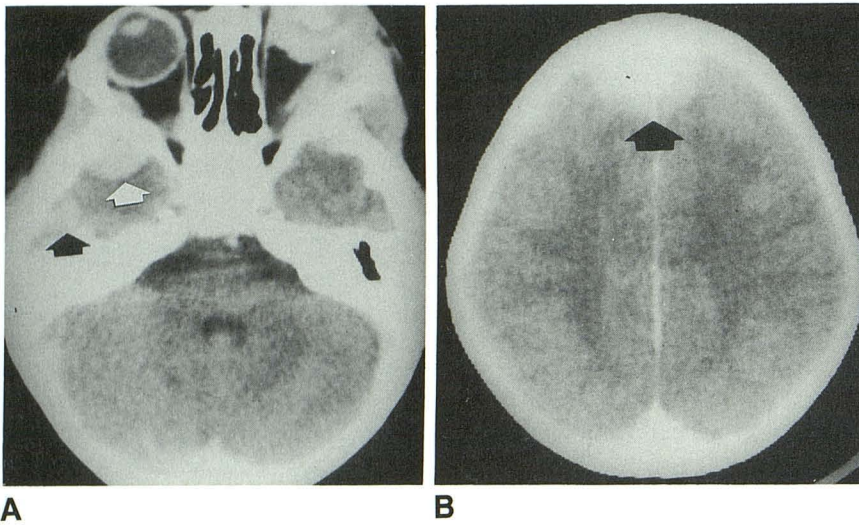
A and B, Retinoblastoma in left eye. Postcontrast CT scans show multiple epidural metastases (arrows) and calcification and enhancement in left globe.
